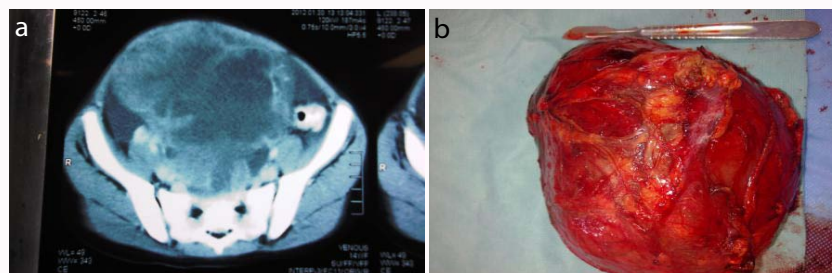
Patient 1 in Table 1. a) Pelvic CT shows schwannoma as heterogeneous pelvic abdominal mass in the rectovaginal space not adherent to uterus or rectum posterior. b) Resected tumor with margin and intact capsule.
